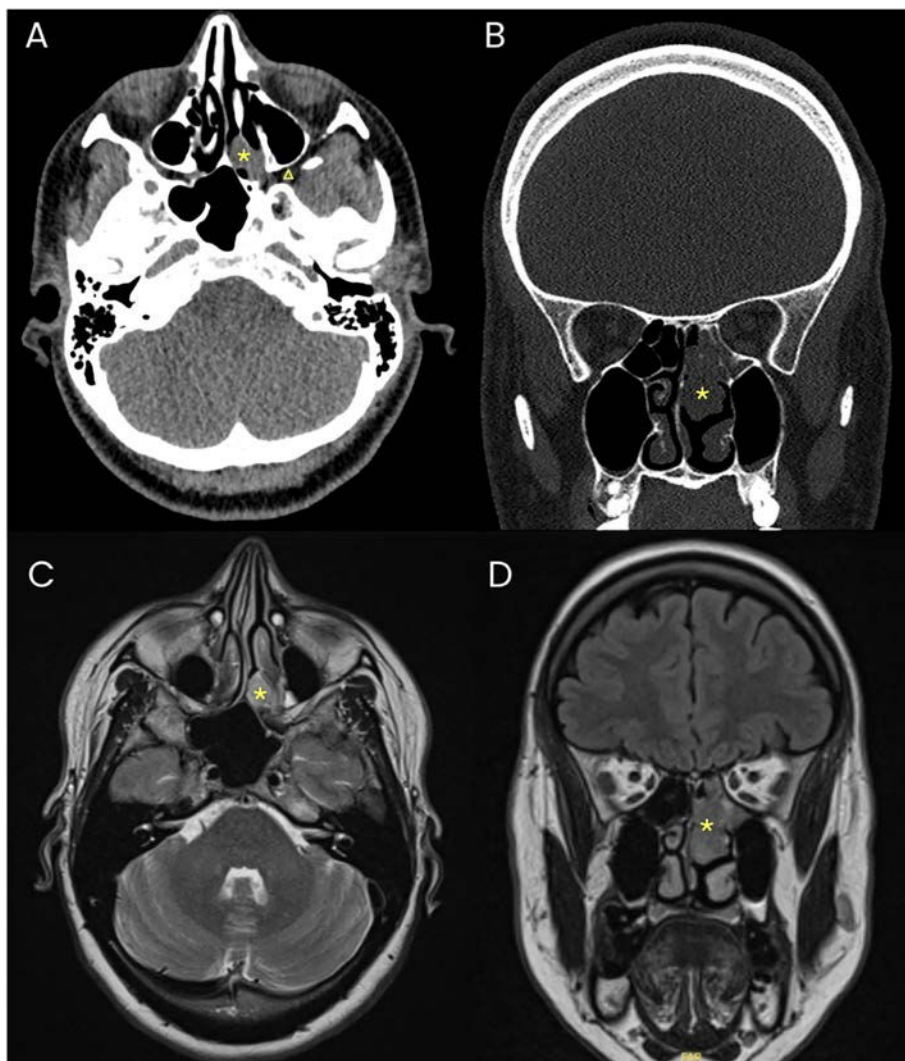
Computed tomography (CT), axial (A) and coronal section (B) and magnetic resonance imaging (MRI), axial (C) and coronal section (D). Sinonasal tumor located in the posterior portion of the left nasal cavity measuring 2.5 cm in longitudinal axis, with extension to the ethmoidal cells and ipsilateral sphenoid sinus (*). The tumor was in contact with the sphenopalatine foramen (Δ) but without significant invasion into the pterygopalatine fossa.
